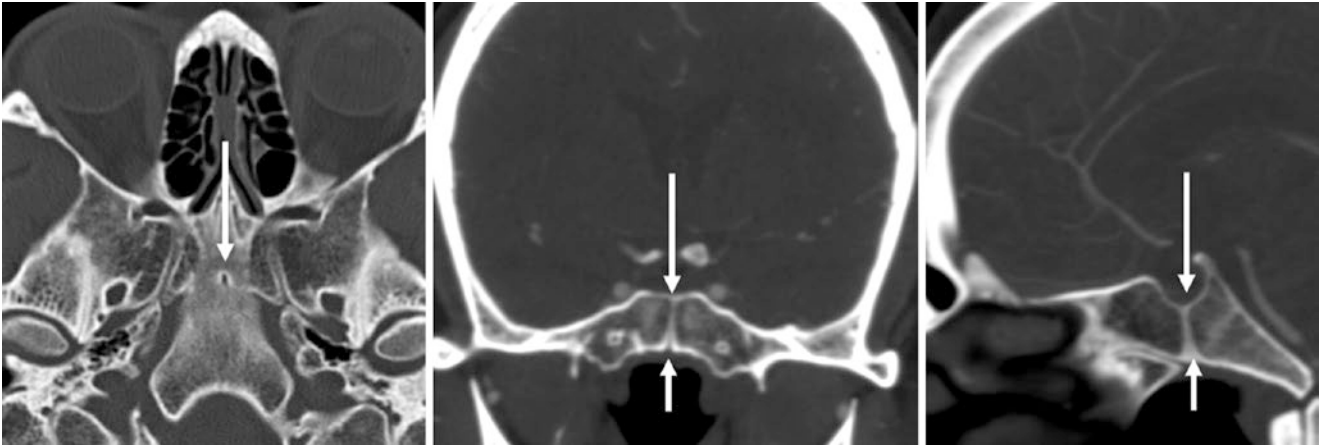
A 50 year old with a patent PF (CPC) that is visible on axial (*left*), coronal (*middle*), and sagittal (*right*) images reconstructed from a CT angiogram. Note the fused SOS situated posteriorly
